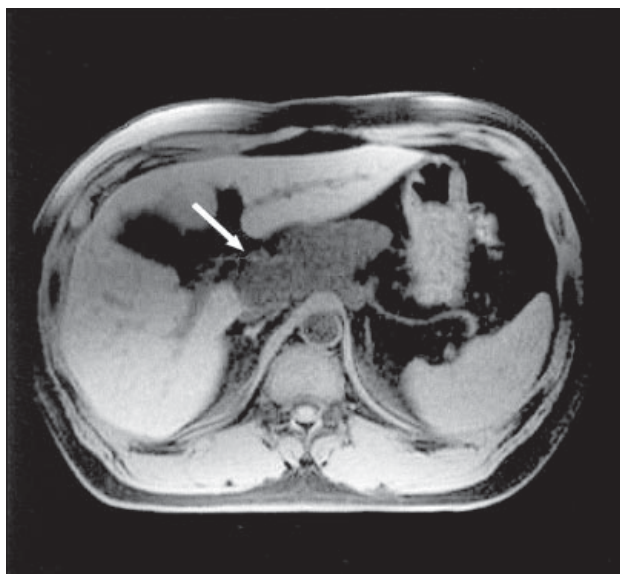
T1-weighted magnetic resonance image shows hypointense signal of the lesion.
